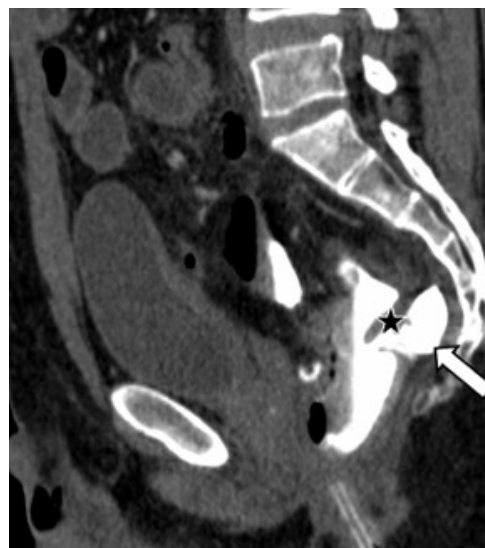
Sagittal CT image demonstrating contrast media leakage (asterisk) forming a pre sacral collection featuring the double rectum sign (arrow).
